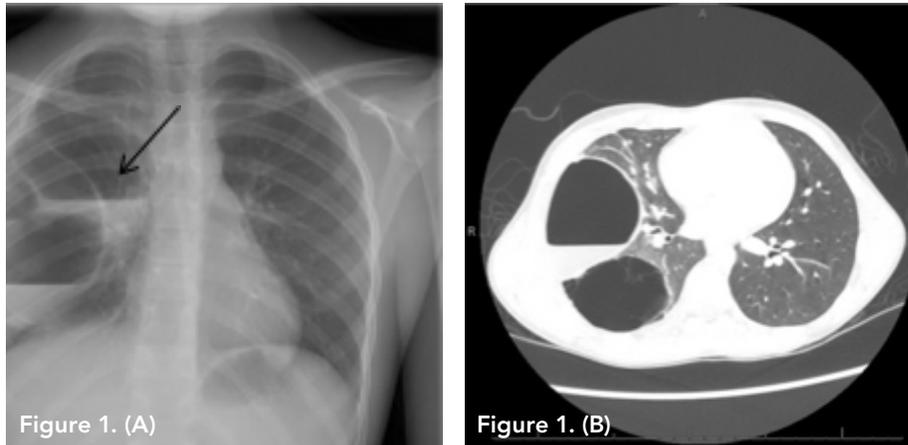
(A) Initial chest x-ray. Black arrow indicates multi-cystic lesions and air-fluid level. (B) Chest CT image. Note lack of parenchymal disease surrounding the cystic lesions and prominent cystic fluid.
